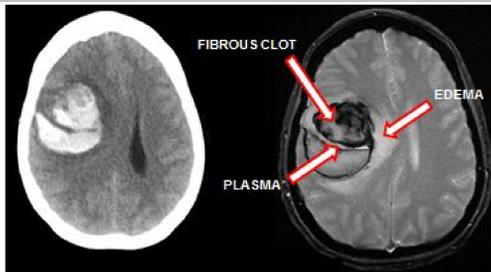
MR image (right) offers greater contrast and definition between the clot, plasma, and surrounding brain matter than CT (left). This allows for more personalized treatment [3]
